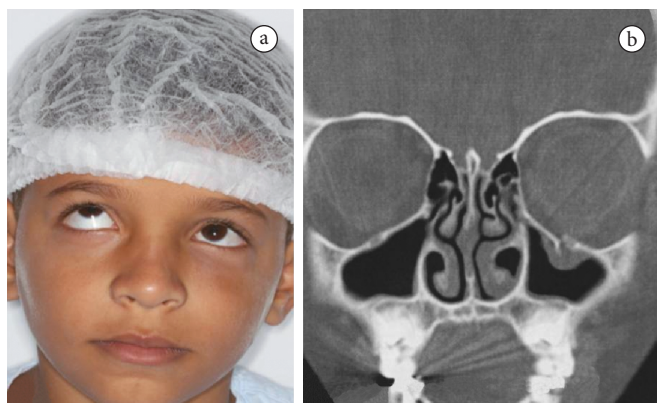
a) Clinical aspect presents the patient with limitation of eye movement. b) Computed tomography (coronal section) showing the fracture of the orbital floor.
